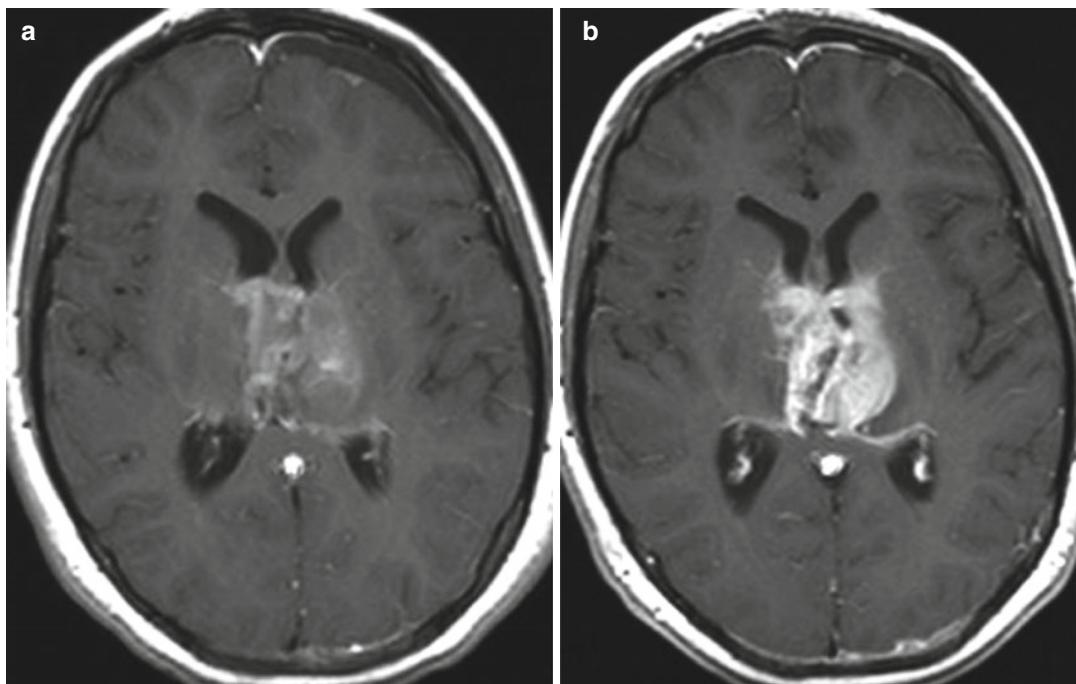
Pseudoprogression: Temporarily increasing and intensified enhancement after chemoradiation of an anaplastic astrocytoma of the thalami (b). (a: MRI prior to RT)
